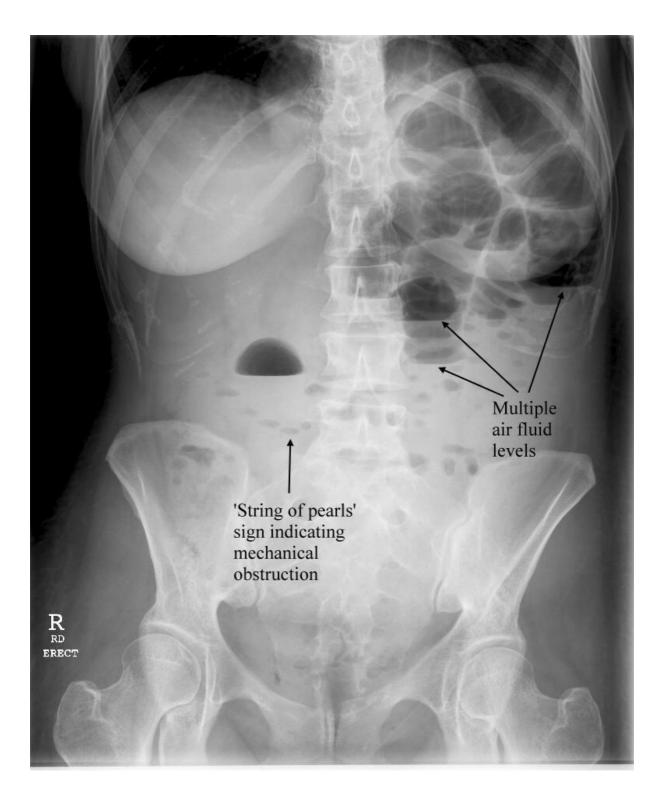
X-ray : String of Pearls Sign
